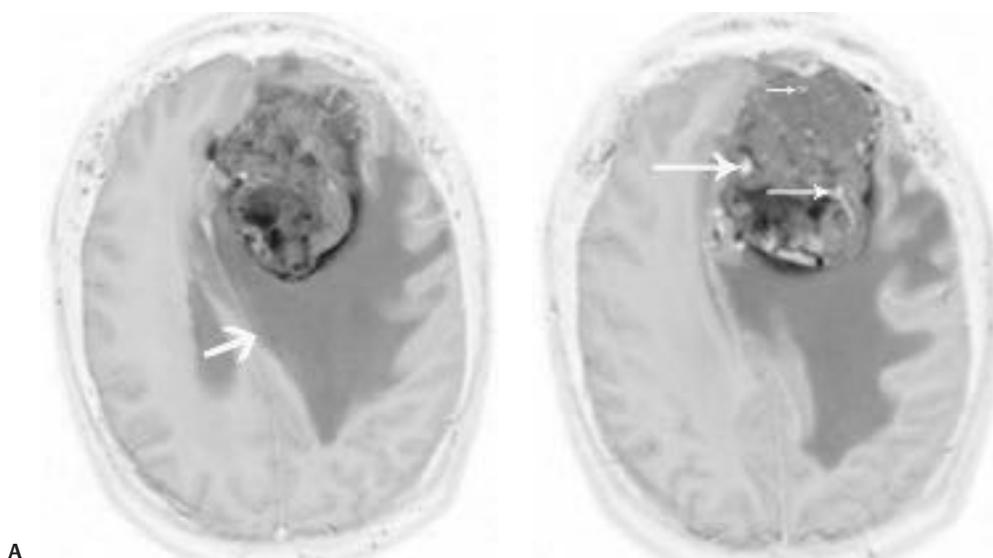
Twenty-six-year-old male with frontal meningioma. Axial T2-weighted images demonstrate a hypervascular left frontal meningioma with (A) surrounding vasogenic edema (*arrow*) and necrosis. (B) Vascular flow voids are noted within the tumor (*arrows*). Although this degree of edema, necrosis, and hypervascularity might suggest an aggressive or malignant meningioma, the pathological diagnosis was WHO grade I meningioma.
